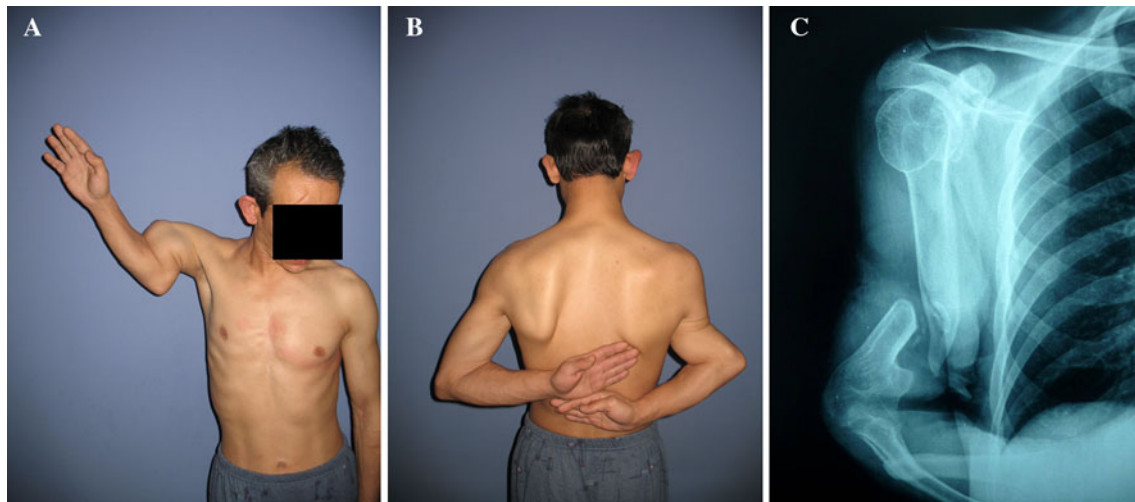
a–c Preoperative clinical situation and radiographs of the patient
